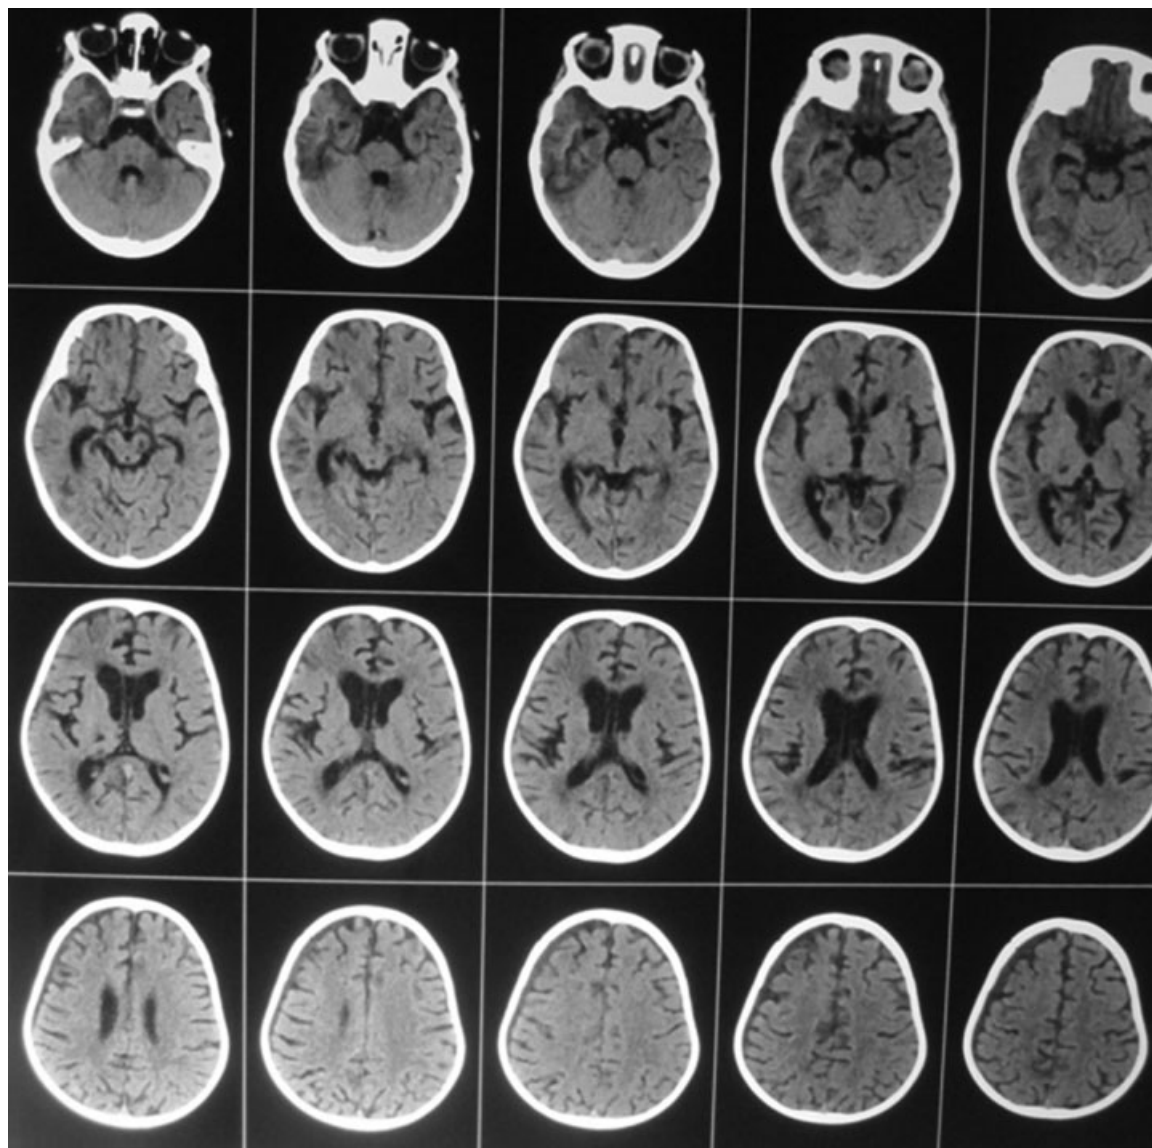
CT brain 12 hours after second scan showing complete disappearance of SDH. CT, computed tomography; SDH, subdural hematoma.
